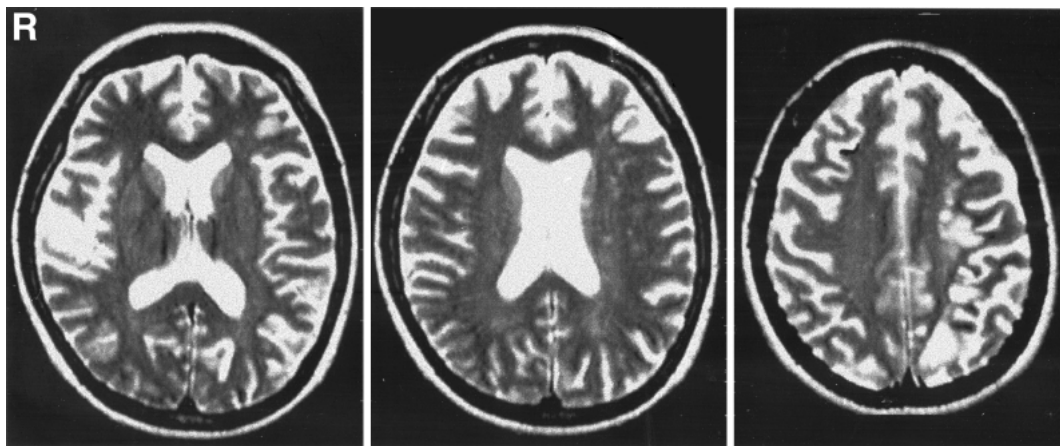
Axial T₂-weighted magnetic resonance (MR) images obtained 8 days after the stent-in-stent procedure at the level of the basal ganglia (*left*), corona radiata (*center*), and centrum semiovale (*right*). The patient manifested no infarcts except for the abnormalities detected on diffusion-weighted MR imaging at the time of admission.
